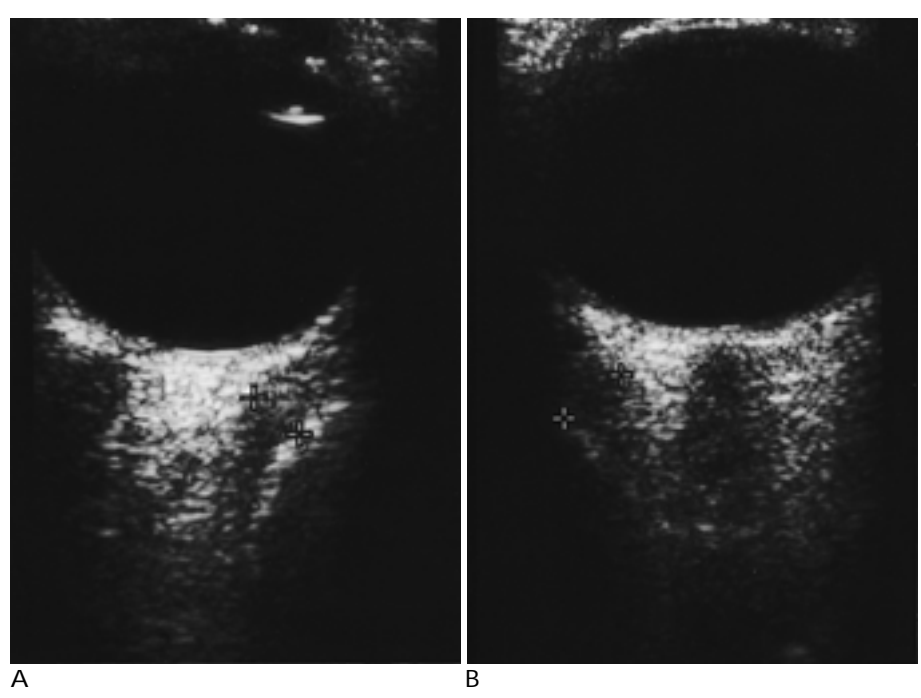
An example of the measurement of medial rectus muscle on transverse (A) and superior rectus muscle complex on longitudinal (B) sonograms in a patient with thyroid ophthalmopathy.
